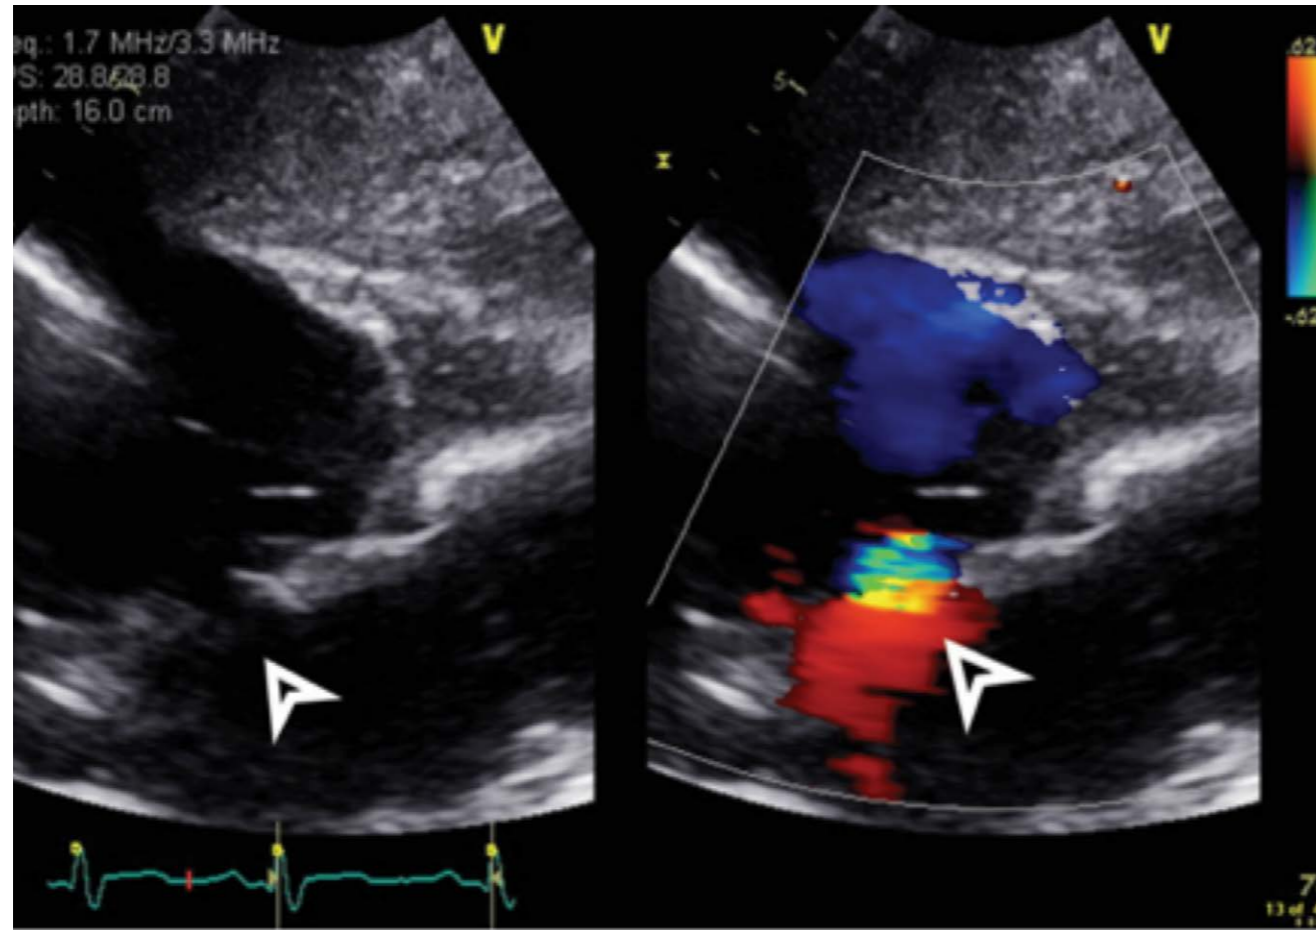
Secundum ASD with shunt (arrows) seen on transthoracic echocardiogram subcostal view.
